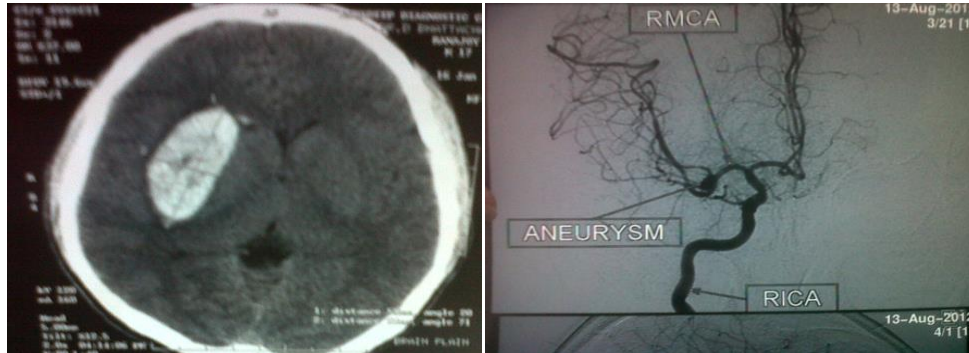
Shows the Aetiology of haemorrhagic stroke & Fig. 4: NCCT (Non-contrast Computed Tomography) Shows the hypertensive intracranial bleed
